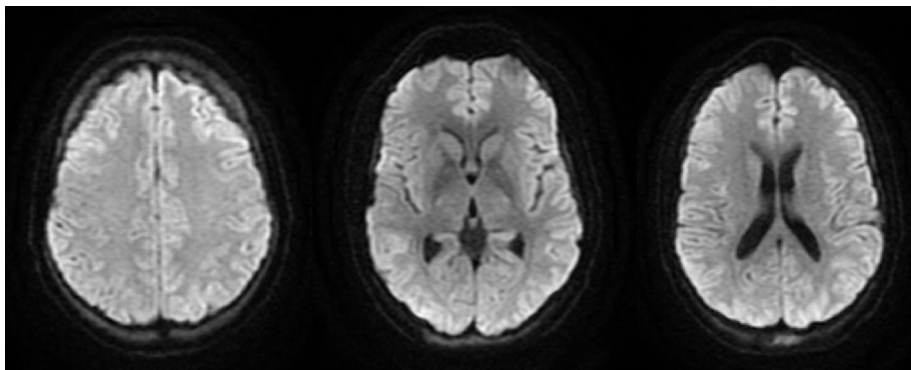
DWI sequence, brain MRI showing diffuse cortical diffusion restrictions.
